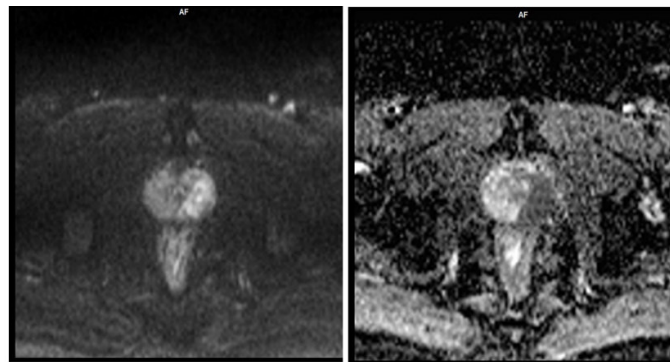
DWI and ADC images showing diffusion restriction in involved left part of prostate.
